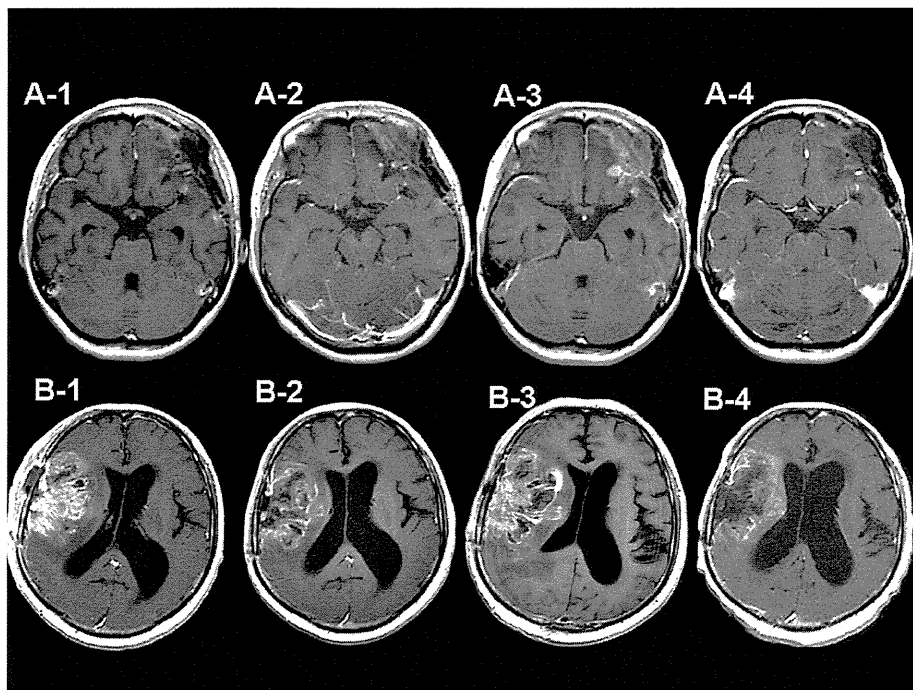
Two representative cases of pseudoprogession of recurrent malignant meningiomas treated by boron neutron capture therapy (BNCT). (A-1–A-4) Gadolinium (Gd)-enhanced MR images of case 50: prior to BNCT (A-1), 48 h after BNCT (A-2), 1 month after BNCT (A-3), and 2 months after BNCT (A-4). (B-1–B-4) Gd-enhanced MR images of case 56: prior to BNCT (B-1), 1.5 months after BNCT (B-2), 2.5 months after BNCT (B-3), and 6 months after BNCT (B-4).
